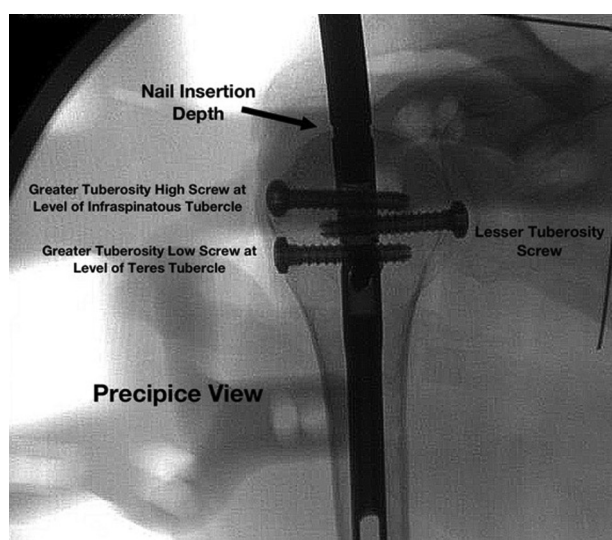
Precipice radiographic view following nail placement. The guide is still attached to the implant on this image.
